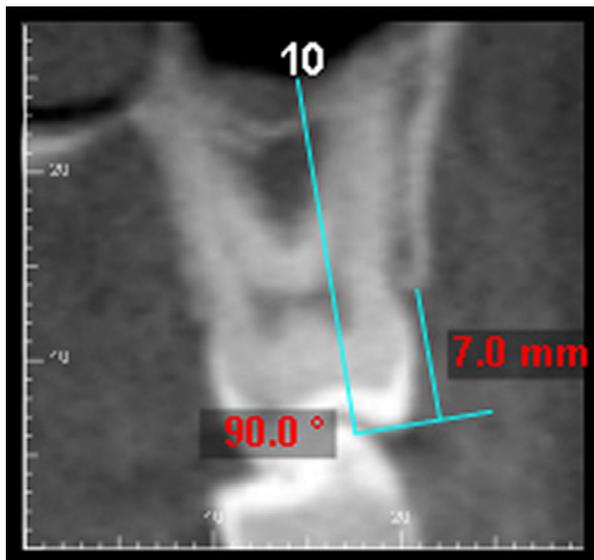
Radiographic image showing BACL.
